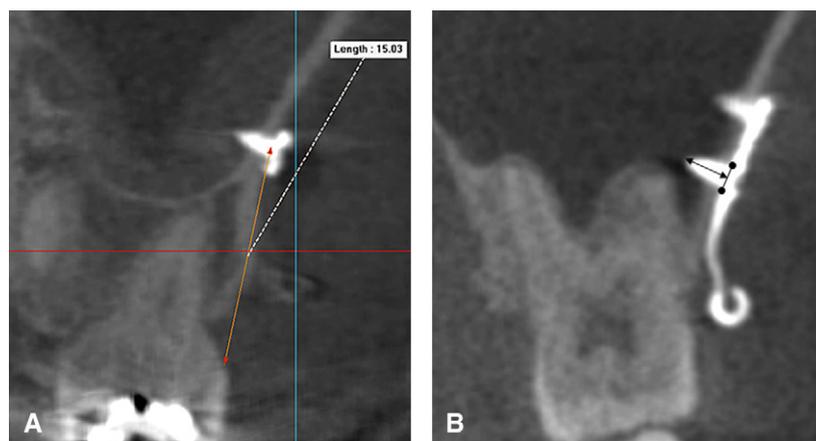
CBCT images of frontal view of the miniplate: A, vertical distance from the CEJ to the center of the miniscrew (PH); B, PD of the miniscrew from the cortical surface to the apex of the miniscrew.
